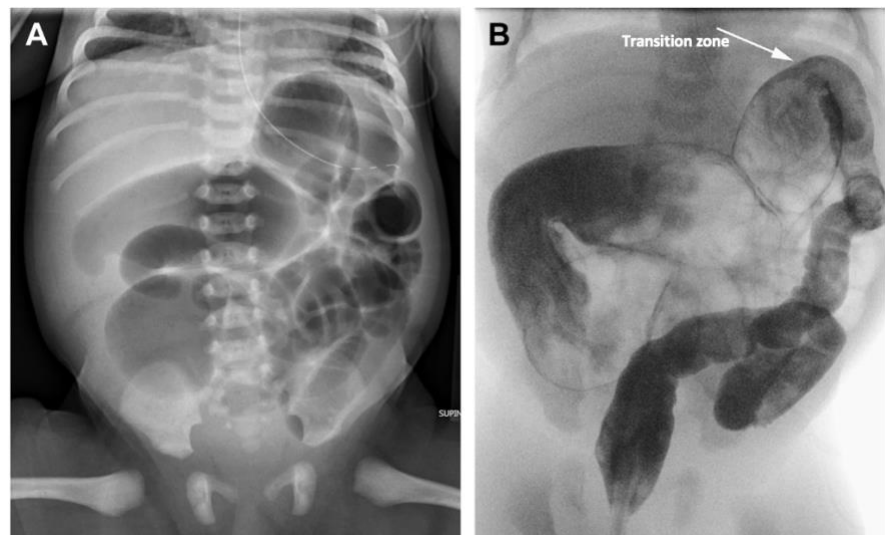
(A) Plain abdominal radiograph showing multiple dilated bowel loop without gas in the rectum. (B) Water-soluble contrast enema demonstrating transition zone and multiple filling defects.
